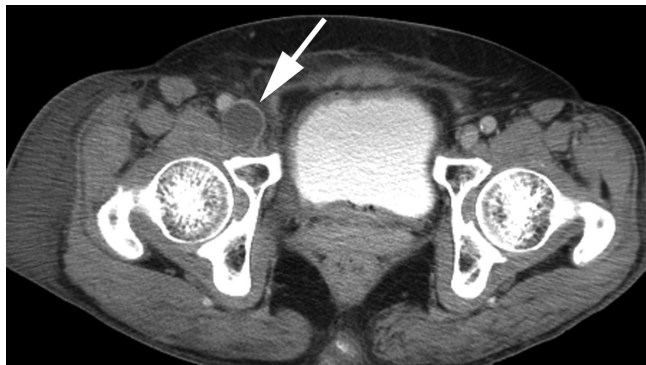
The CT scan shows a cystic mass compressing the right common femoral vein (white arrow).
